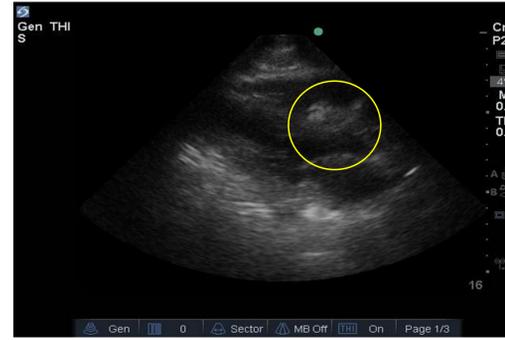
Parasternal long axis image identifies opacity in right ventricle
